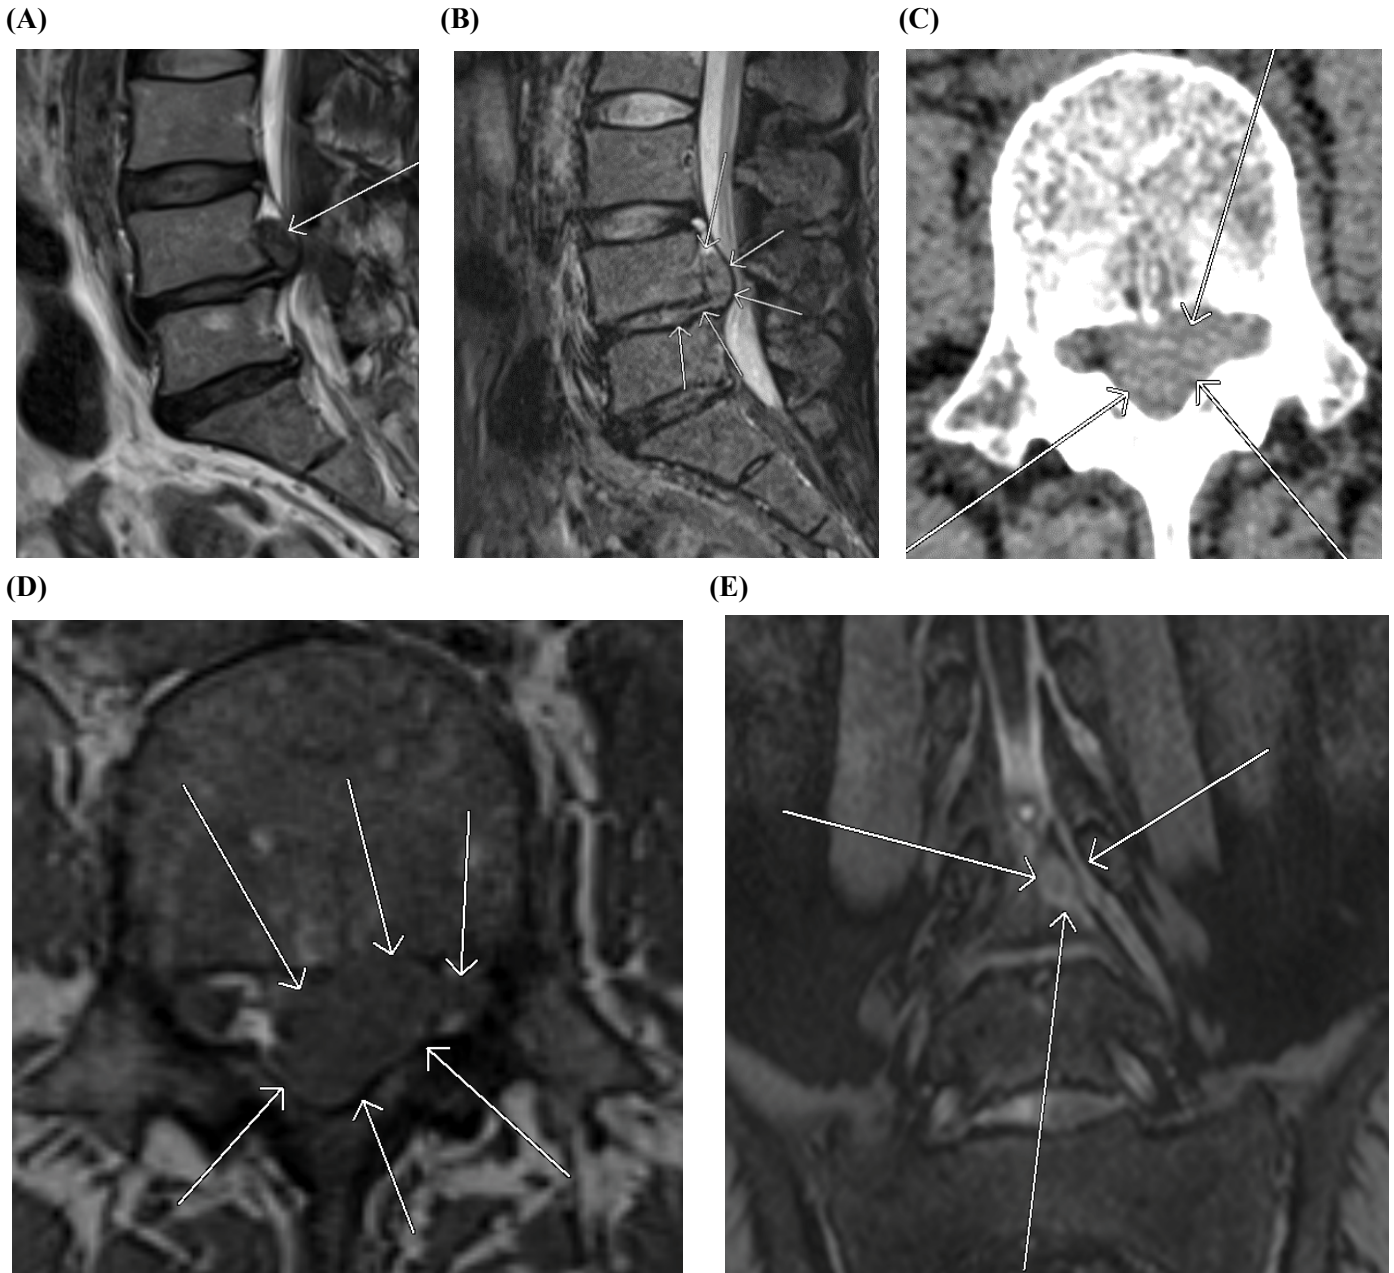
of case1: (A) sagittal T2-weighted MRI, showing an extruded disc of L4/5 with the nucleus pulposus moving upwards, located in the spinal canal behind the L4 vertebral body, showing an oval low-signal nodule (indicated by arrow). (B) Sagittal T2-weighted MRI with fat suppression shows the signal of the extruded nucleus pulposus is similar to that of the maternal nucleus pulposus and is connected with a narrow and long neck (indicated by arrows). The cauda equina nerve behind the extruded nucleus pulposus is compressed and thinned. (C) Cross-sectional CT image of the middle level of the L4 vertebral body, it can be seen that there is an irregular soft tissue (indicated by arrows) in front of the cauda equina nerve in the spinal canal, and the boundary is not clear. (D) Axial T1-weighted MRI of the middle level of the L4 vertebral body. The oval low signal nodules in front of the cauda equina nerve in the spinal canal can be seen. The fat space around the nerve root of the right lateral recess is clearly visible, while the nerve root and fat space of the left lateral recess are blurred. (E) Coronal T2-weighted SPACE image, shows that the free nucleus pulposus is located above the L4/5 intervertebral space, and the left L4 nerve root lateral recess is compressed and thinned by the nucleus pulposus (arrows).
